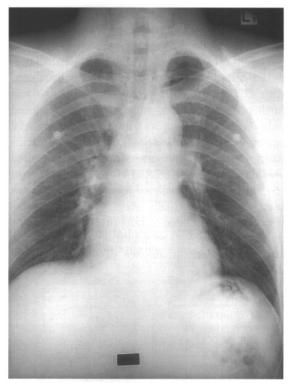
Pulmonary barotrauma of ascent: chest X-ray showing mediastinal emphysema causing the 'tram track' sign, from air stripping the pleura from the edge of the cardiac shadow.
